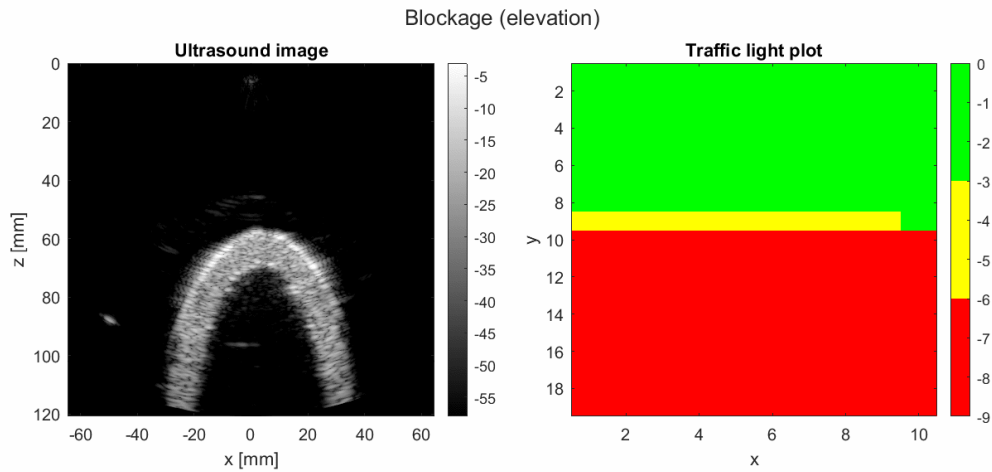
The harmonic ultrasound image and the traffic light plot of the case where the plastic box is blocking some of the elements in the elevation direction.
